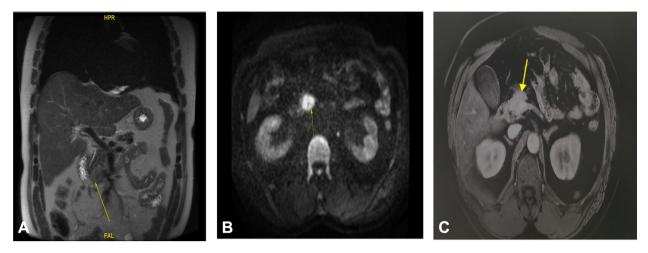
Magnetic resonance imaging upon diagnosis *A*, T2 image. *B*, Diffusion image. *C*, post-contrast image showing a 3.2 × 2.5-cm well-circumscribed hypervascular lesion (arrow) centered at the uncinate process of the pancreas, showing mild washout on delayed post-contrast images, with corresponding intermediate bright signal intensity on T2-weighted image and diffuse restriction.
